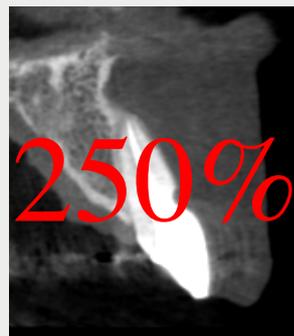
Cone beam computed tomography: tooth 11.
